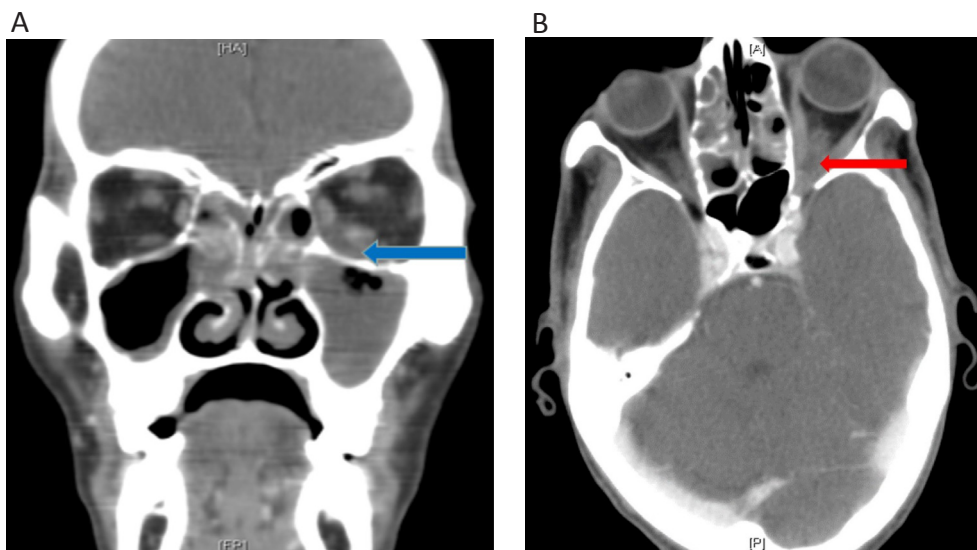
73 year old patient presenting with pain in the left side of face and orbit. (A) Coronal CT shows soft tissue density involving both ethmoid sinus and left maxillary sinus with extension into extraconal space of the left orbit (blue arrow). (B) Axial CT shows soft tissue density in the orbital apex region (red arrow).
